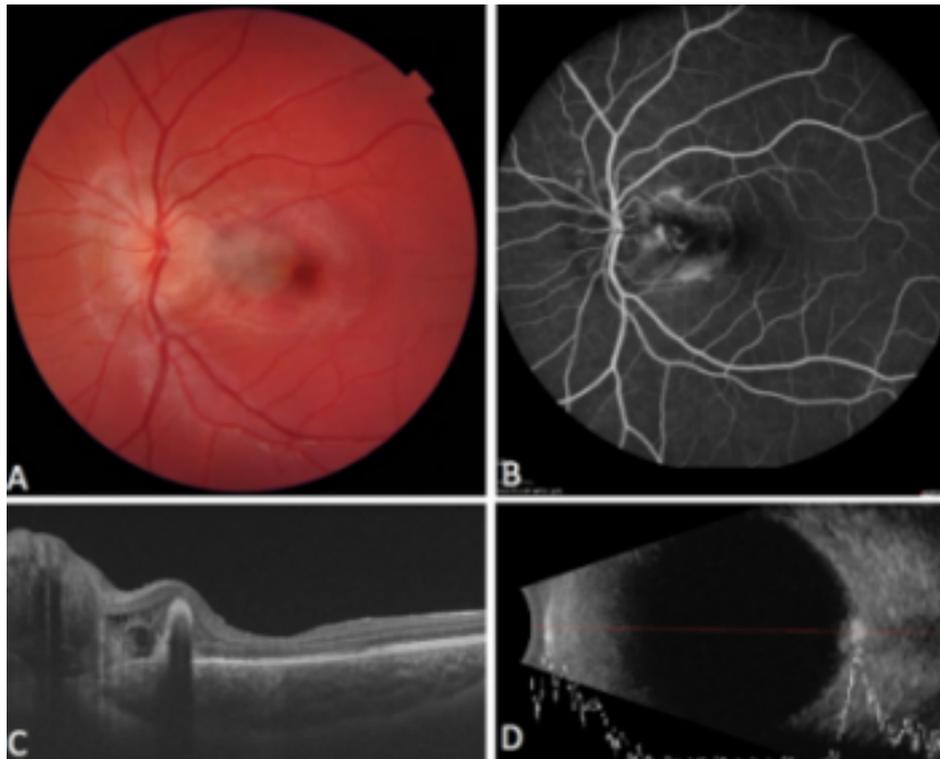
A) Funduscopy revealed a prominent and blurry optic disc with subretinal hemorrhage spreading towards the edge of the macula region; B) CNVM made visible through mid-phase IVFA; C) OCT scan with ODD and parapapillary cystoid edema, subretinal scarring; D) Shallow but prominent ODD are revealed through hyperreflectivity in low-gain mode using ultrasound.
